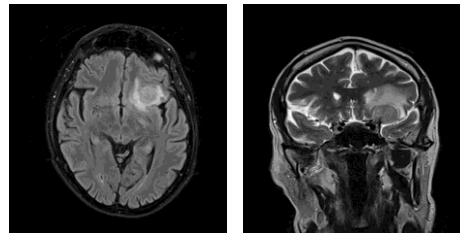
MRI section showing a left fronto-orbital lesion: meningioma.
